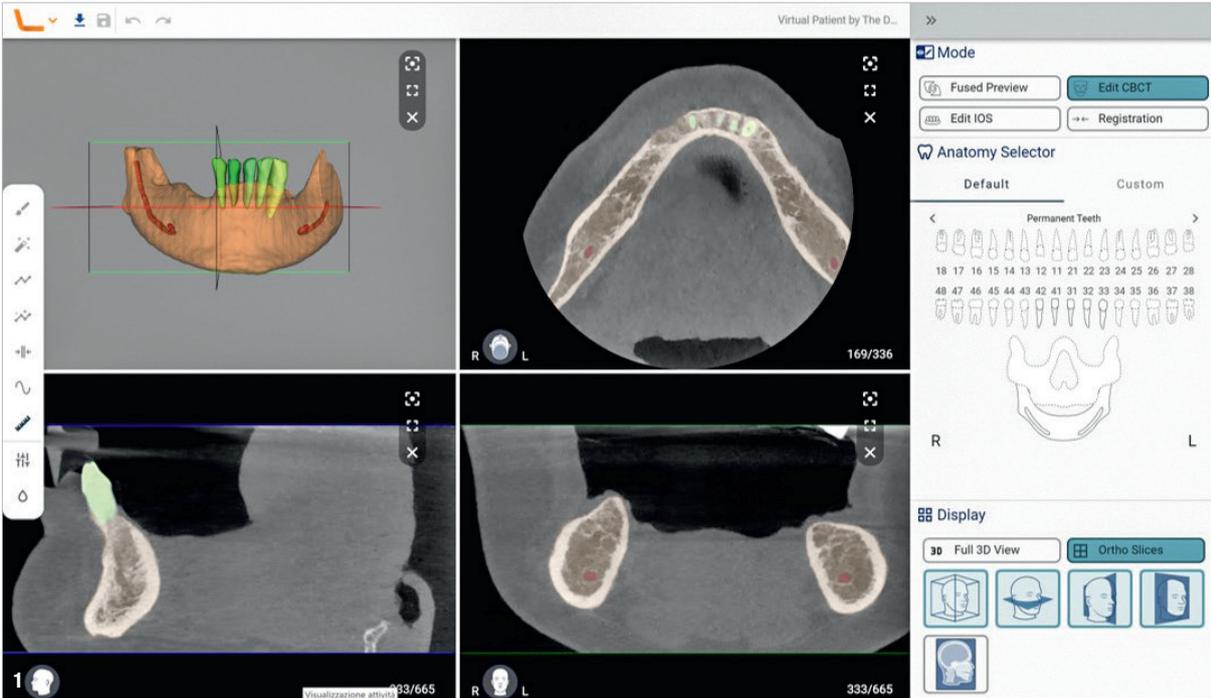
Automatic segmentation from CBCT in Relu's artificial intelligence-assisted, cloud-based software.
